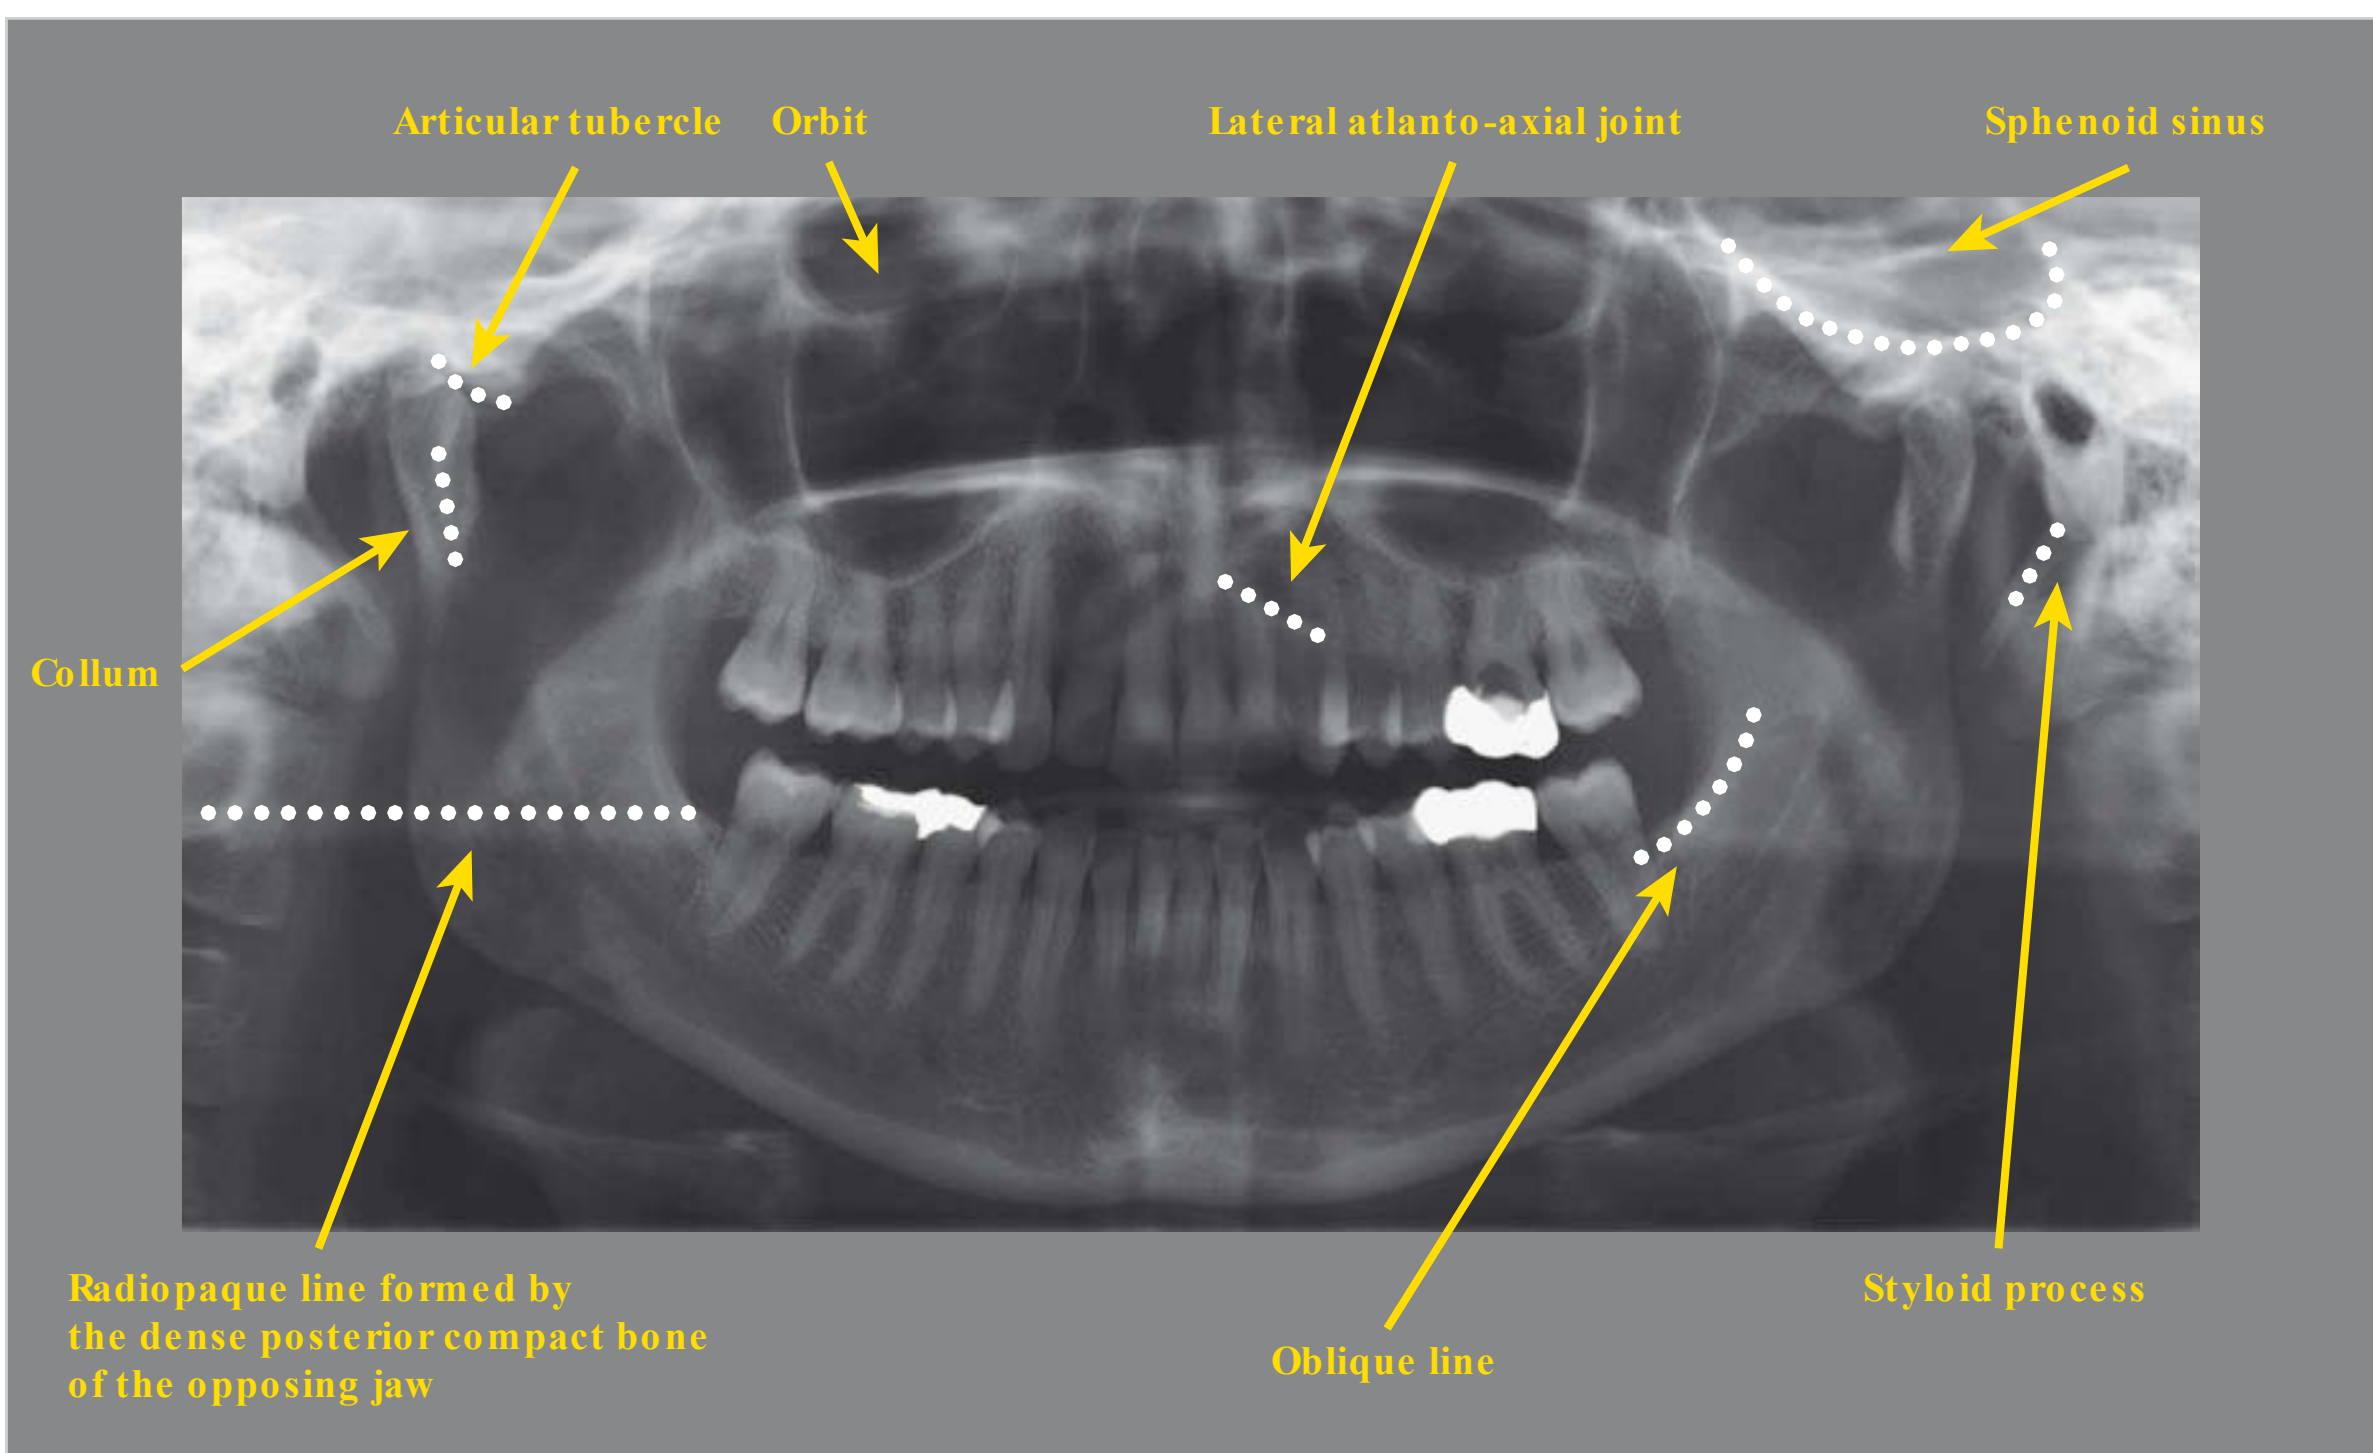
Panoramic radiography: anatomical structures II.
